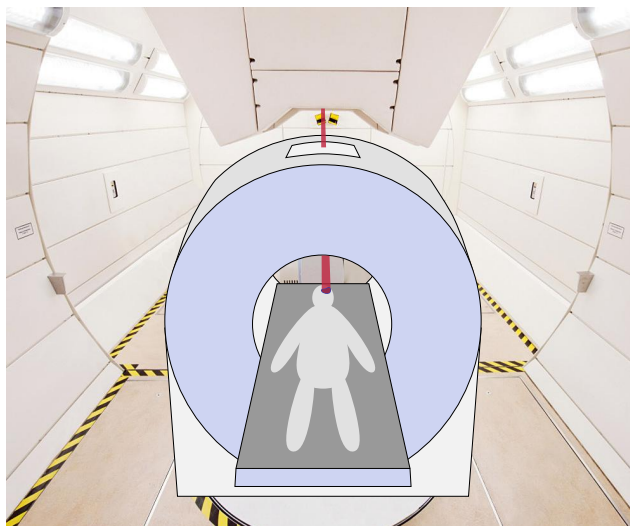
Vision for the future: ion beam applicator (beam nozzle in the upper part of the image) combined with a MRI scanner. Such a hybrid device would allow for real-time imaging and treatment plan adaptation to anatomical changes during irradiation of a patient (photomontage, original image adopted from <http://www.klinikum.uni-heidelberg.de/Gantry-Pressbilder-Stand-Oktober-2012.129328.0.html>, March 10, 2013).
